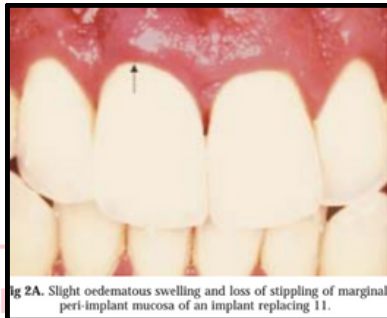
Image- Case with signs of peri implant mucositis without radiographic bone defect (Source article)
